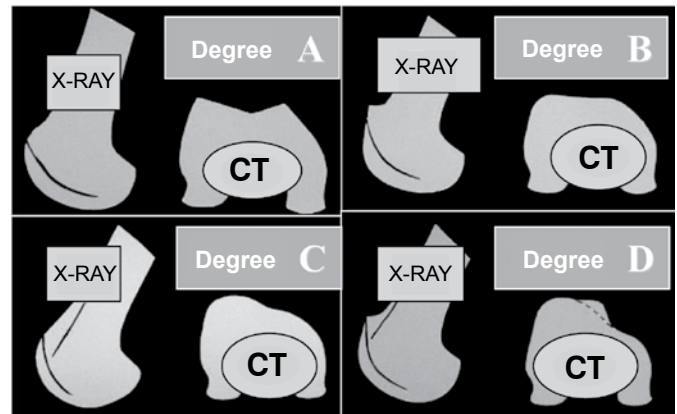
Classification of Trochlear Dysplasia (D.Dejour⁶) (X-ray + CT).
